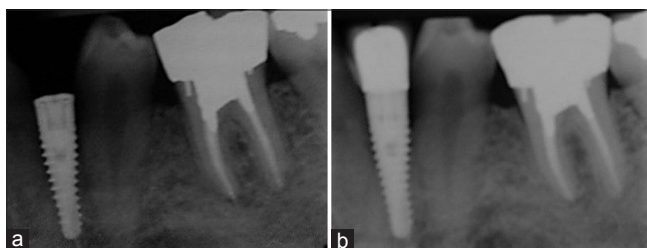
Radiographic image of conical implants (a) at the baseline and (b) 6 months later
